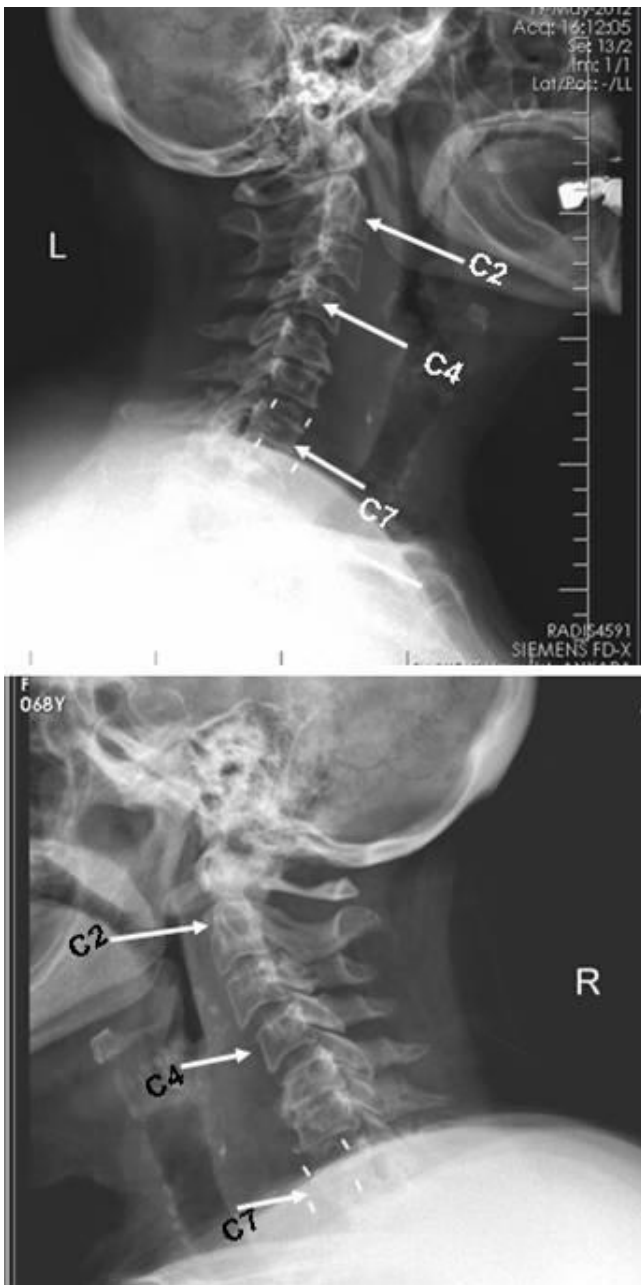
Lateral cervical X-ray shows the PEEK cage's titanium pins. The upper image shows no compression fracture 2 d post surgery; the lower image shows a compression fracture at the C7 vertebral level 3 d post surgery.
